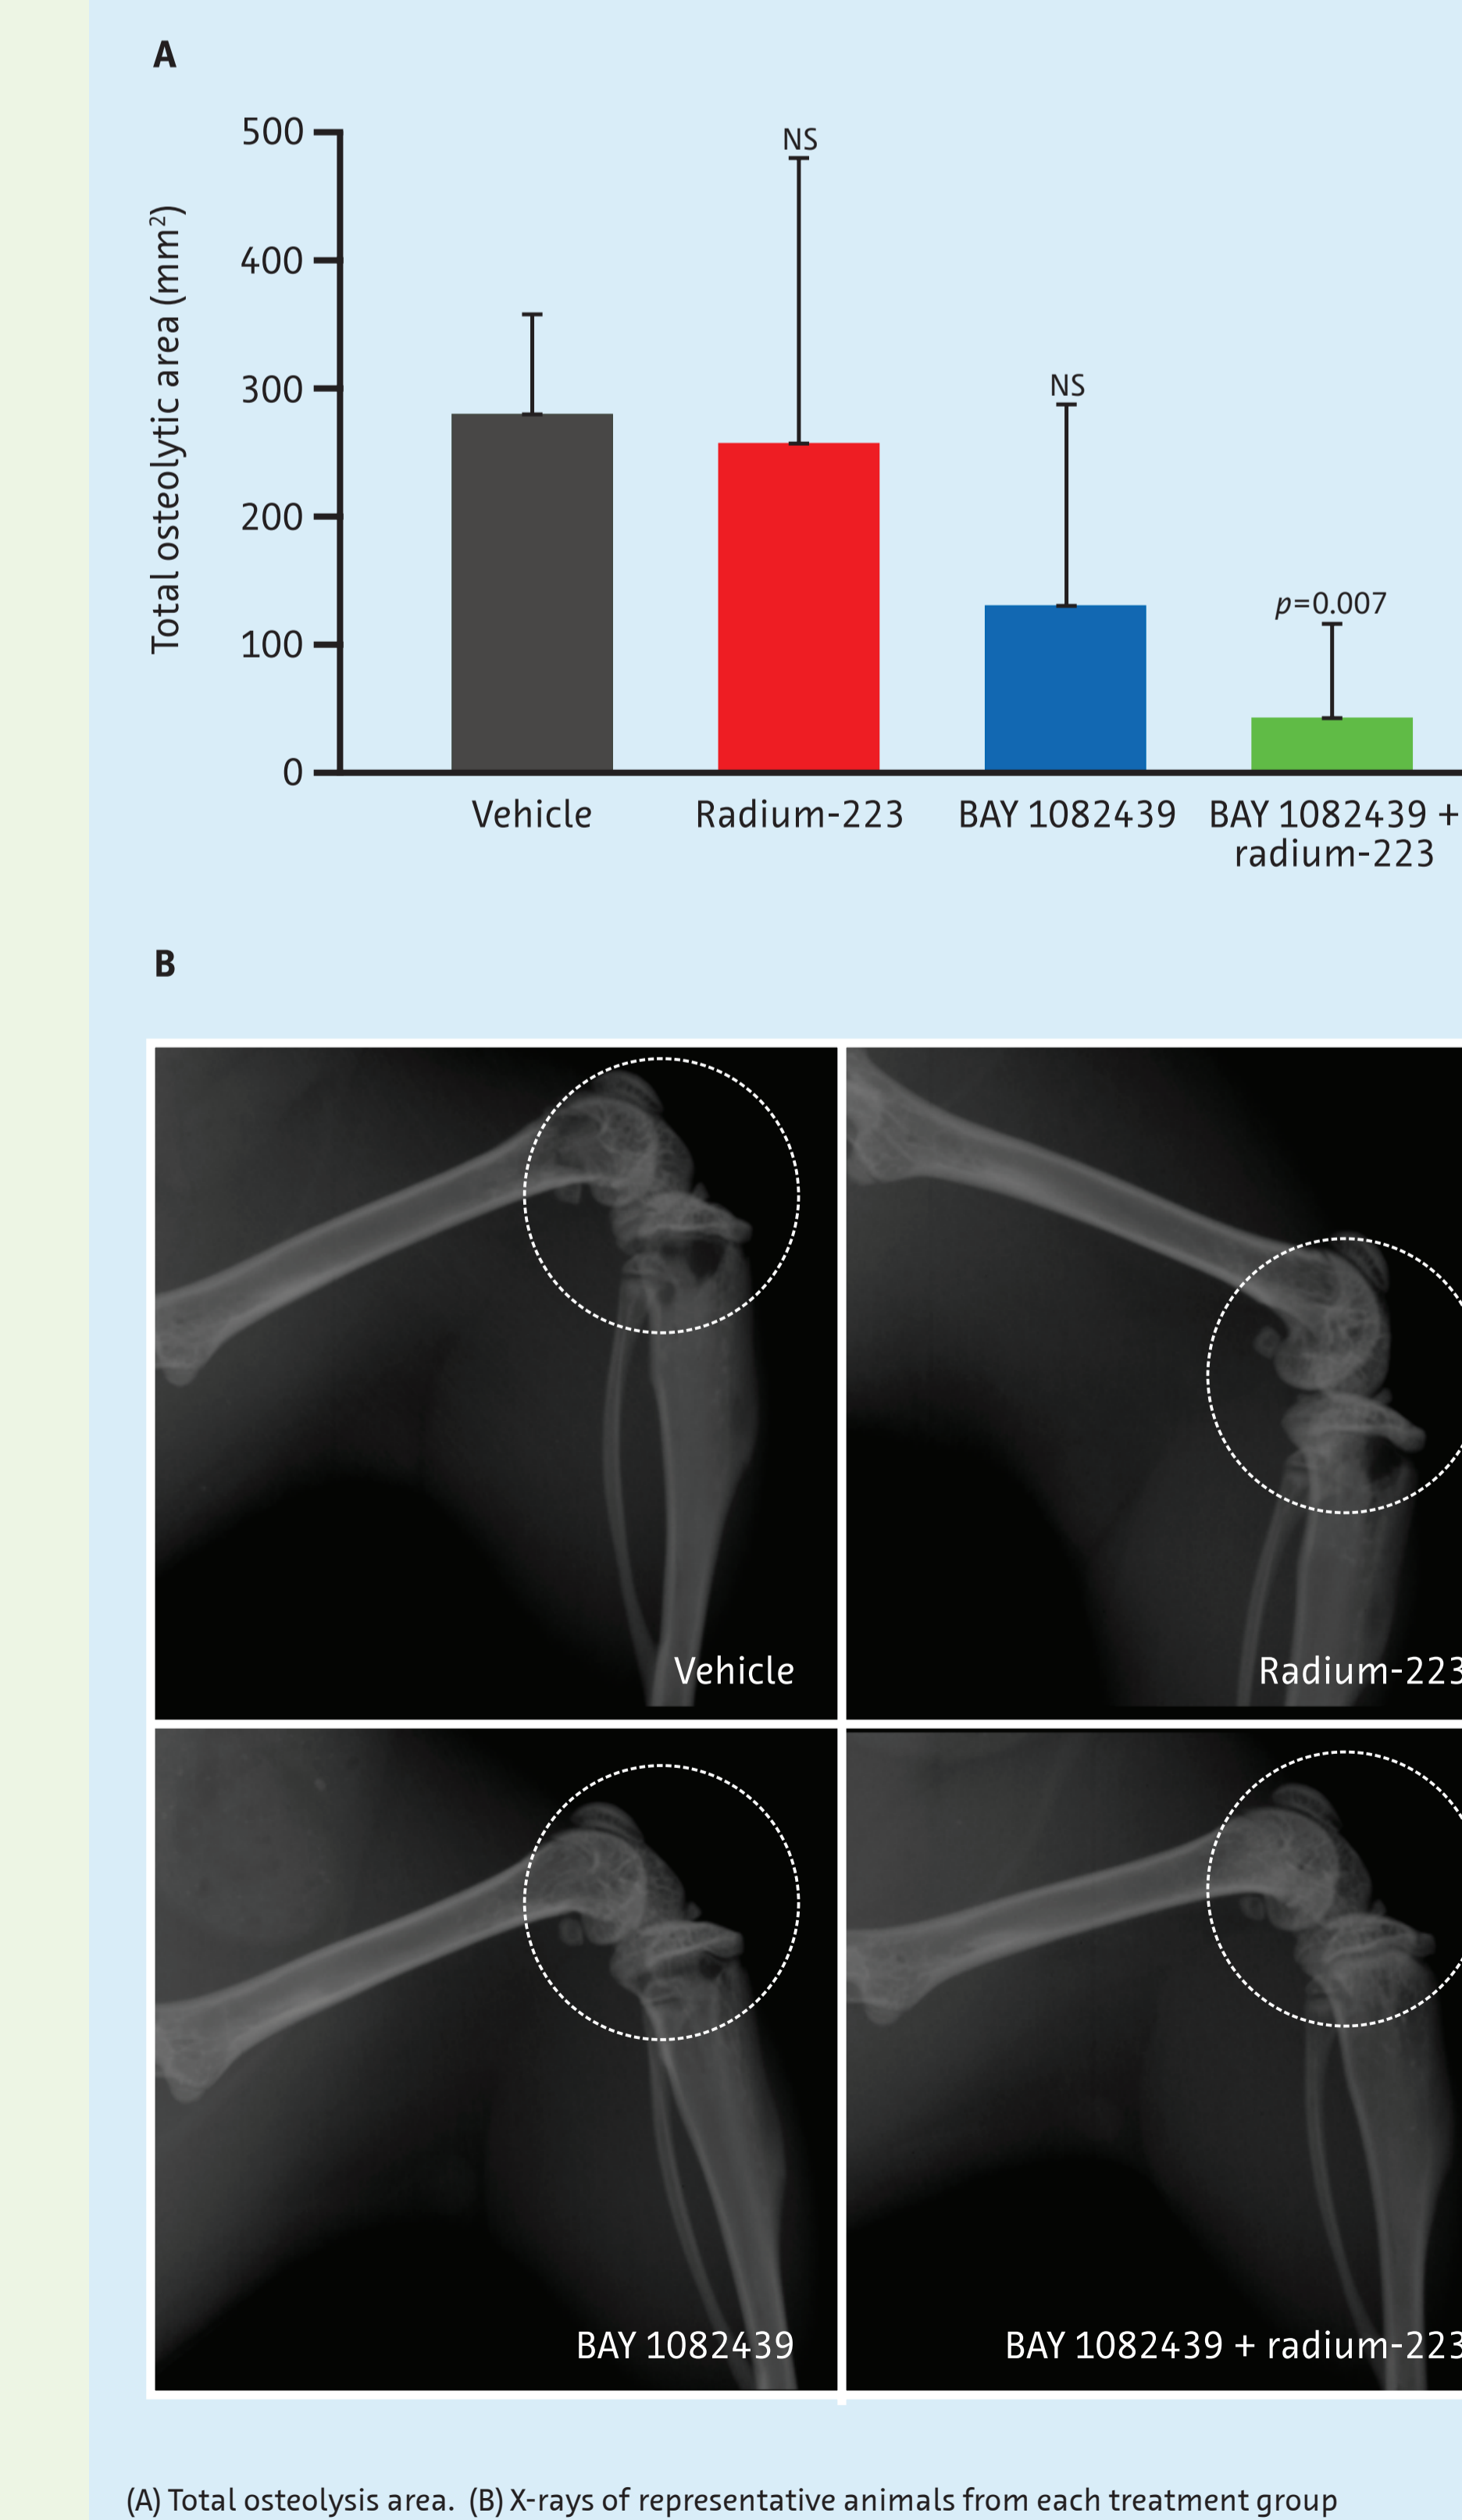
Inhibition of osteolysis by BAY 1082439 and radium-223 measured by radiography
